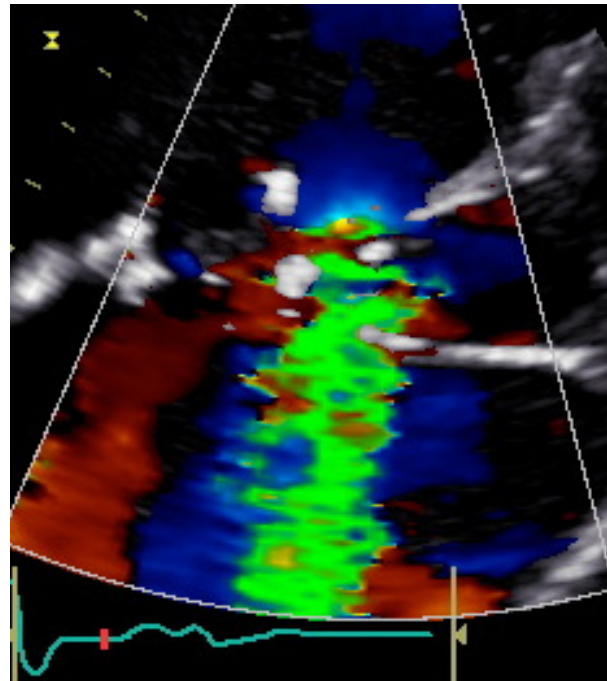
Postsurgical Doppler color echocardiogram shows a severe tricuspid perivalvular leak.
